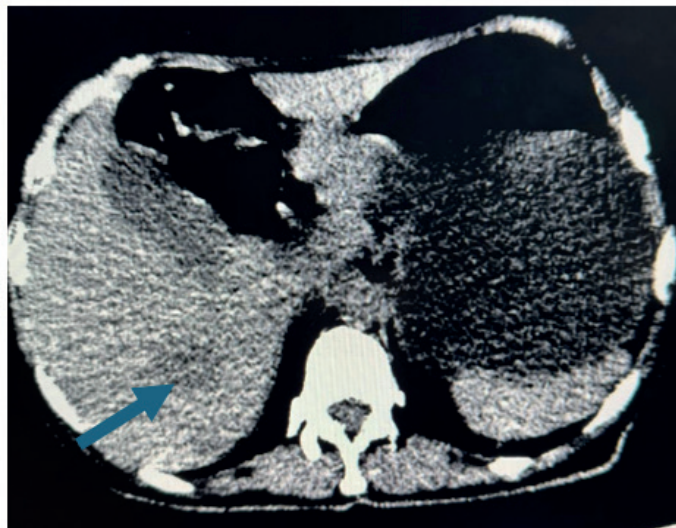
Non-contrast abdominal CT scan showing a liver lesion in segment VI/VII of indeterminate appearance (blue arrow).
